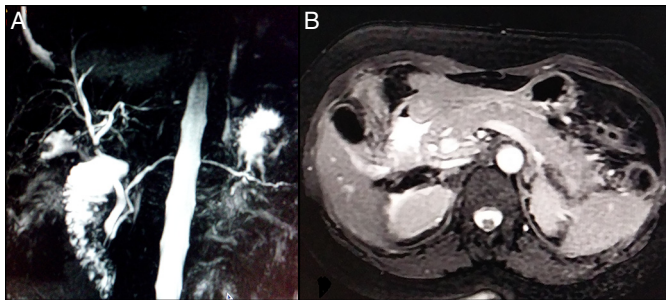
(A) Maximum intensity projection image of abdominal magnetic resonance imaging showing normal biliary tree with mild prominence of the pancreatic duct. (B) Axial section of abdominal magnetic resonance imaging T2 FS images showing a bulky tail of pancreas with mild fat stranding in the tail region.
